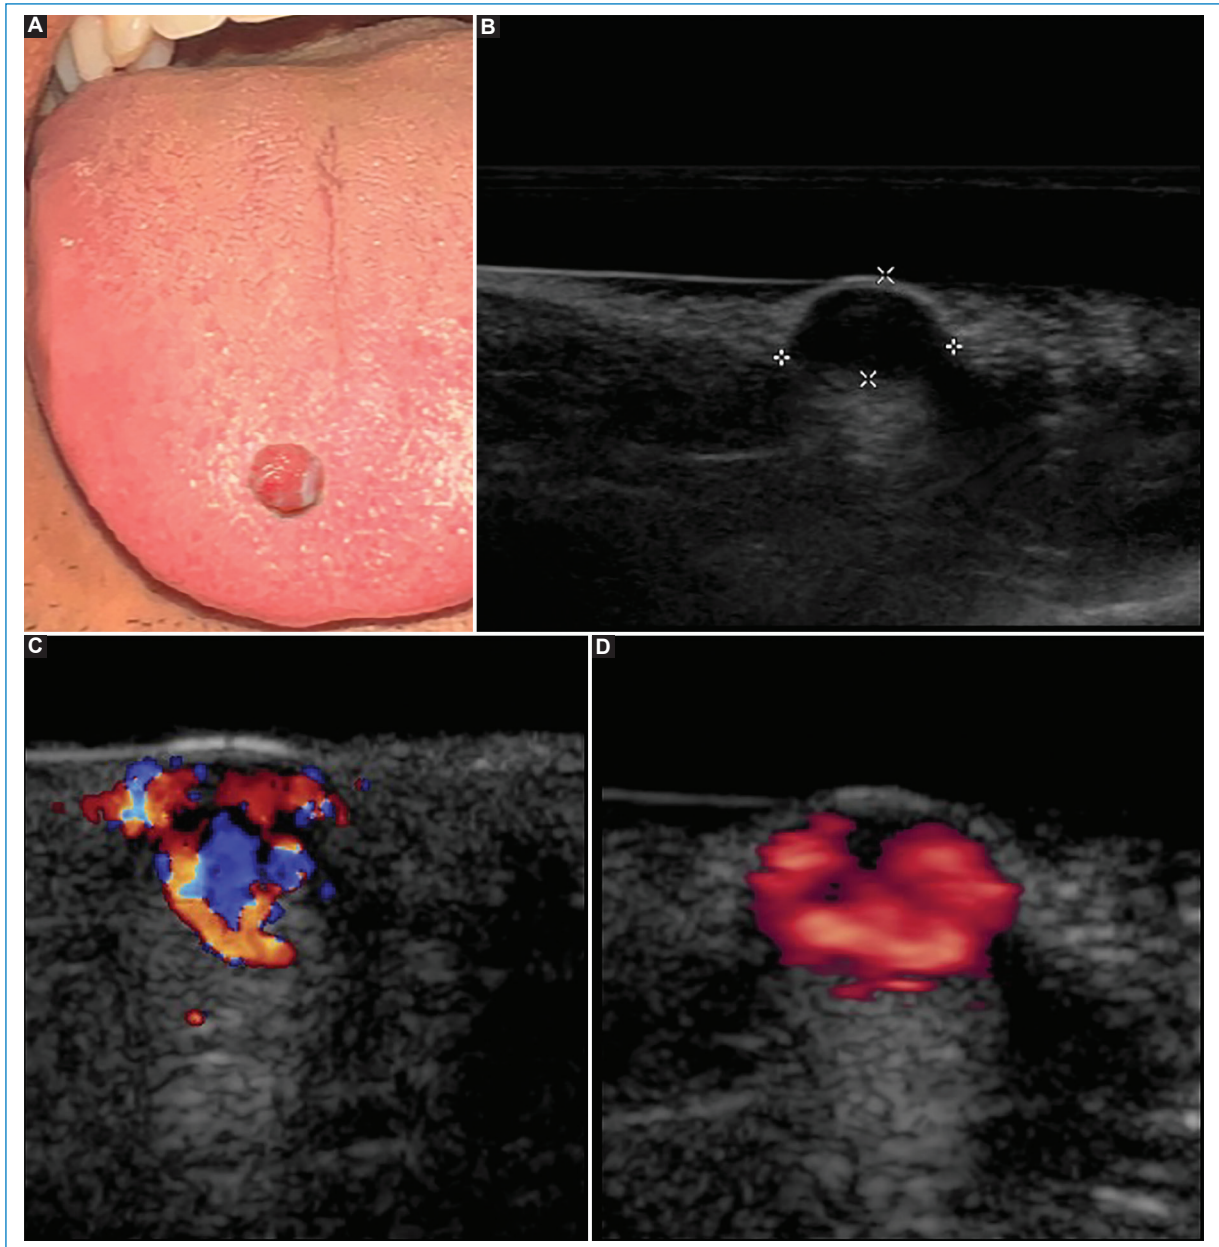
Telangiectatic granuloma visible on physical examination (A). On ultrasound (B) it is observed as a superficial hypoechoic nodule with multiple internal vascular structures, represented in color Doppler (C) and power Doppler (D) modes.
